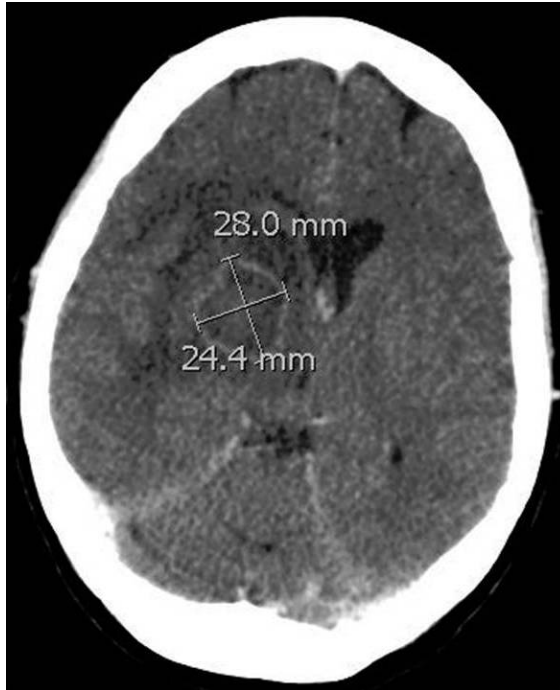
CT scan of brain without IV contrast: A 24.4mm by 28 mm ring enhancing mass is highlighted in the figure. Note the hypodense region surrounding the mass, which represent edema. A leftward midline shift can also be appreciated on this figure.
